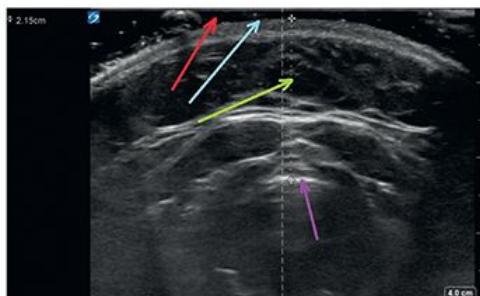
Transverse ultrasound scan for cricothyroid membrane identification in a patient with BMI $>45 \text{ kg/m}^2$. Red arrow refers to ultrasound gel (between transducer and skin); blue arrow refers to skin; green arrow refers to cricothyroid membrane (CTM) depth (21.5 mm as indicated by caliper measurements); purple arrow refers to air-tissue border of the CTM. *Reprinted from Gadd K, Wills K, Harle R, et al. Relationship between severe obesity and depth to the cricothyroid membrane in third-trimester non-labouring parturients: a prospective observational study. Br J Anaesth. 2018;120(5):1033–1039. Copyright © 2018 British Journal of Anaesthesia.*
